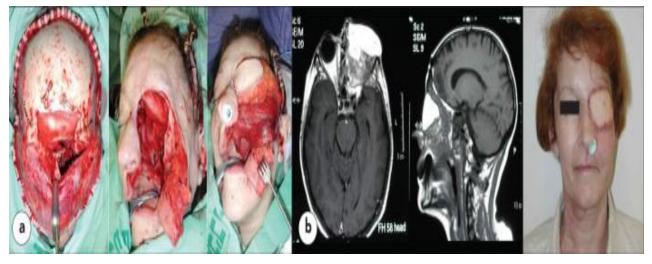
a) Intraoperative view for the subcranial-transorbital combined approach. b) The subcranial-transorbital combined approach. Postoperative CT scans (middle and left) and general appearance (right) are shown ⁽²¹⁾
